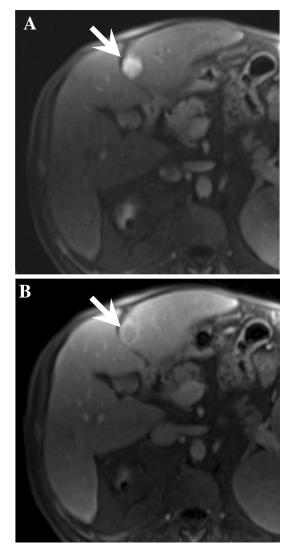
LR-4 (10-19 mm) with APHE and "capsule". Contrast-enhanced MRI in the arterial (A) and delayed (B) phases show an observation (arrow) in the left hepatic lobe of a cirrhotic liver measuring 19 mm exhibiting nonrim arterial phase hyper-enhancement (APHE), and enhancing "capsule", but no "washout' or threshold growth. As with prior versions, this observation is categorized LR-4.
